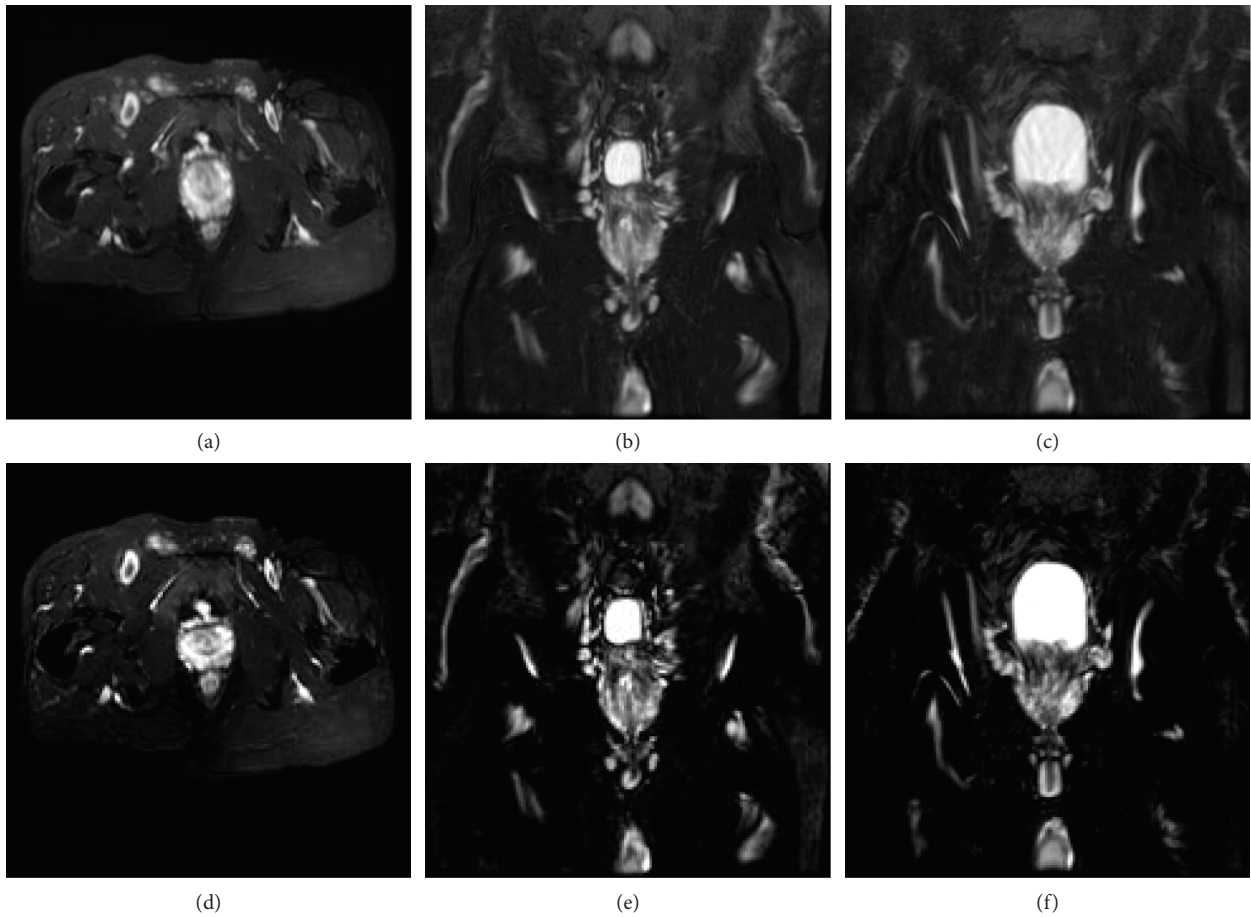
MRI images presentation of the typical case. (a)–(c): pre-processing image; (d)–(f): processed image.
